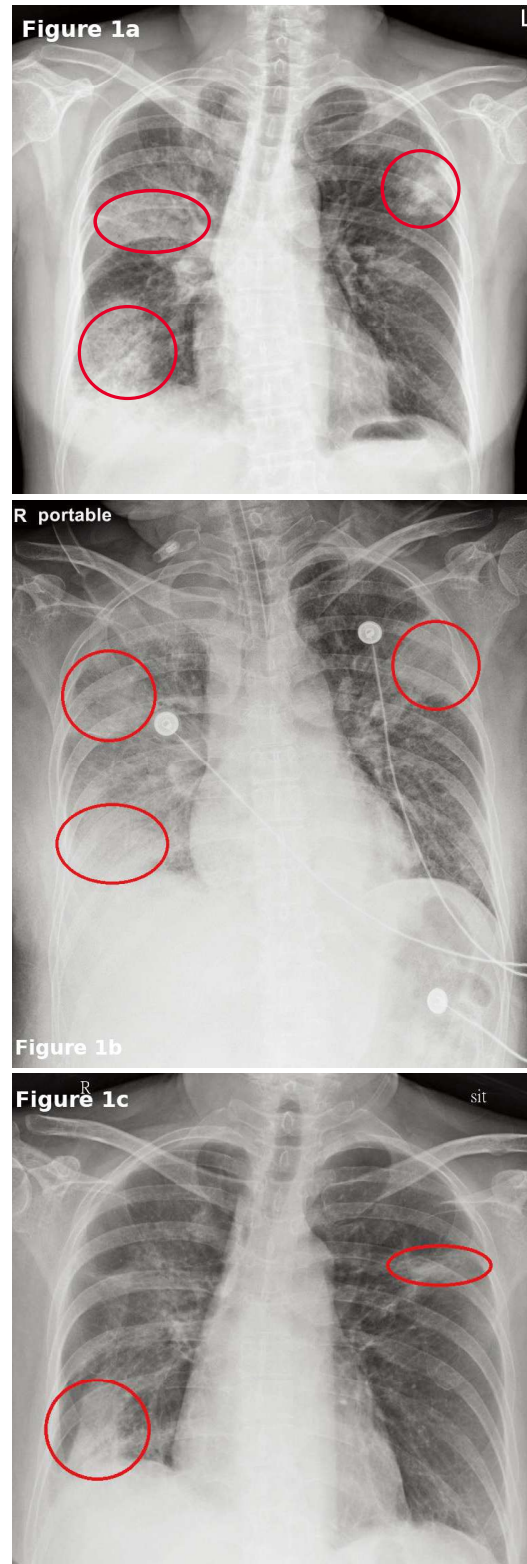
Serial chest X-rays showing disease progression and treatment response. 1a. Chest X-ray on day 1 of admission showing bilateral patchy consolidation. 1b. Chest X-ray on day 6 of admission revealing worsening bilateral infiltration and increased opacities. Endotracheal tube was in place. 1c. Chest X-ray on day 31 of admission showing continued improvement with resolving infiltrates.
